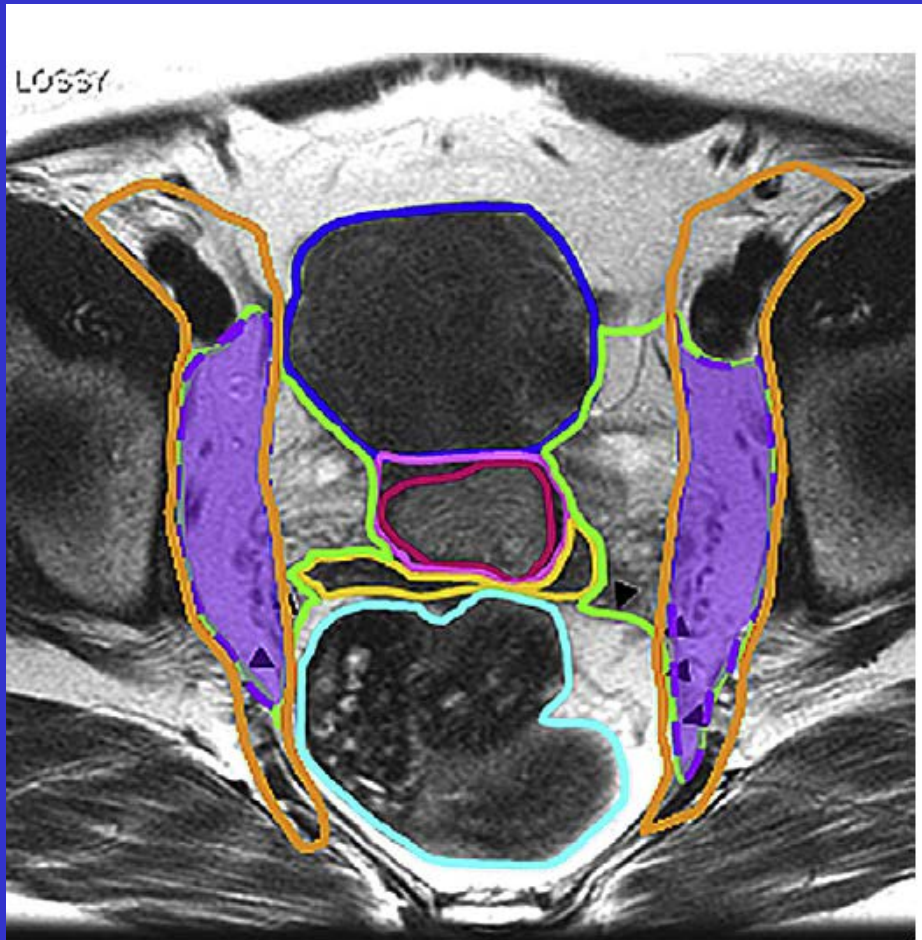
Axial T<sub>2</sub>-weighted MR image showing overlap (purple-shaded region) between nodal clinical target volume (orange contour) and lateral portion of parametrial volume (green contour).
